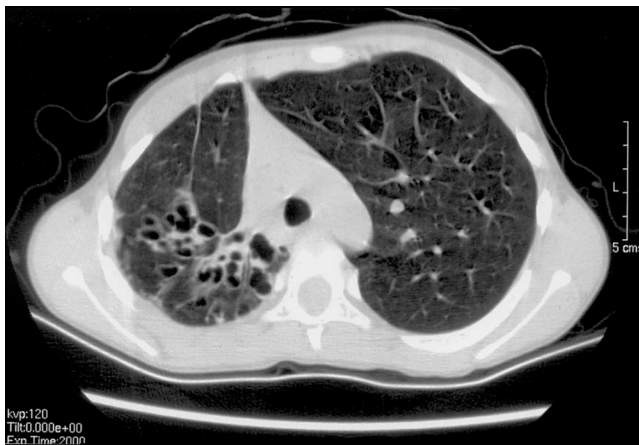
CT scan findings of saccular bronchiectasis in the right upper lobe of a 9-year-old boy.
